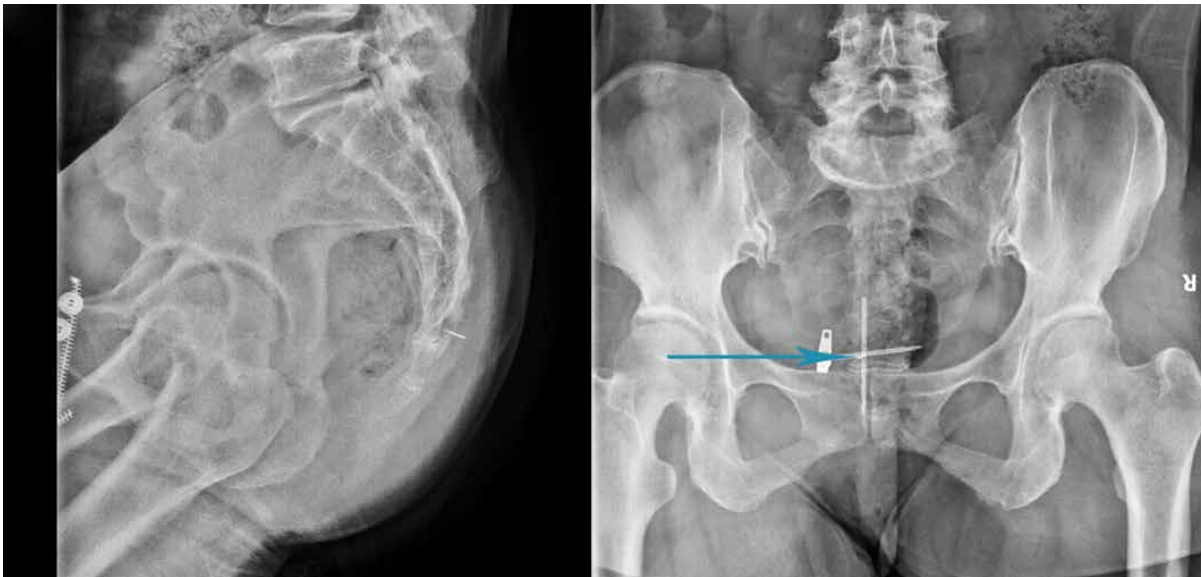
The location of the broken needle in lateral and anteroposterior radiographs, which located in the intersection (cyan arrow) of cross two needles of 20 ml syringe
